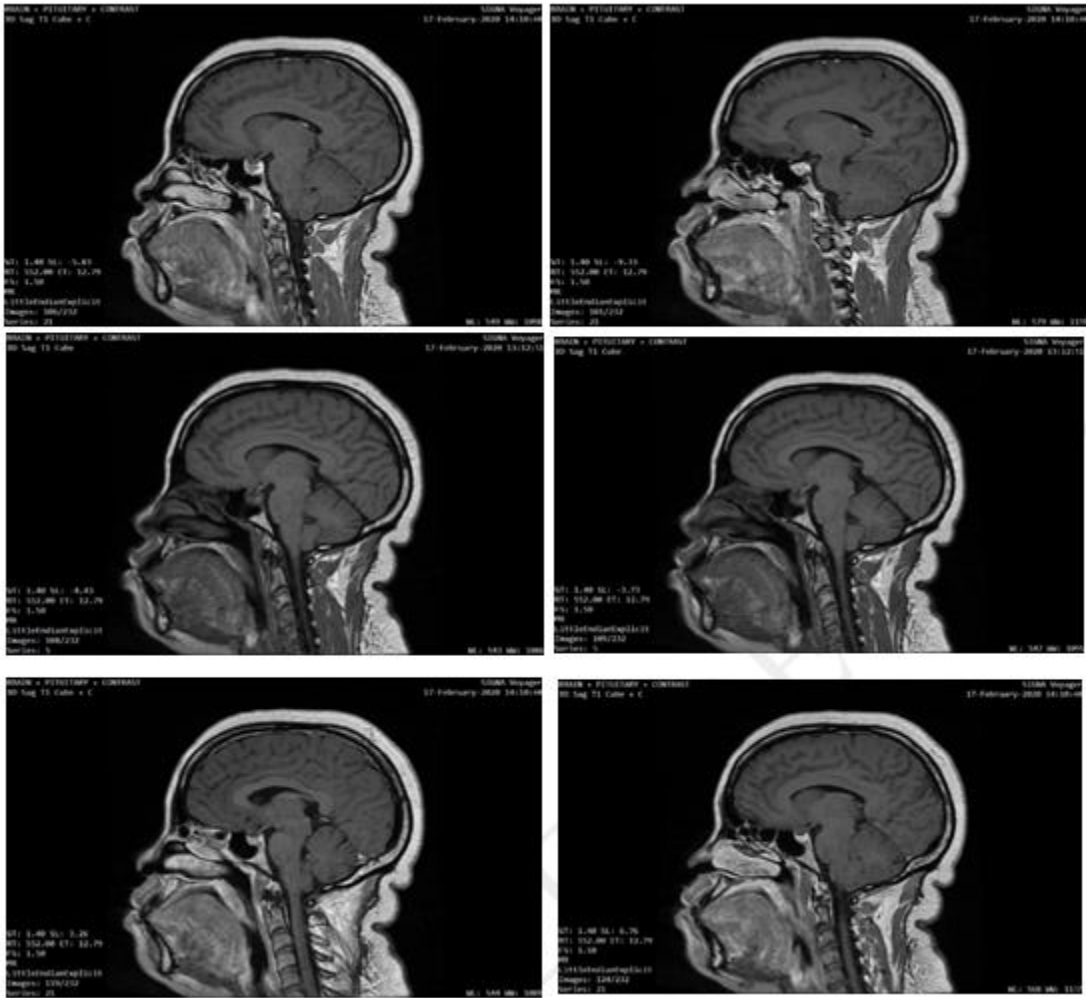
Baseline magnetic resonance imaging (MRI) showing the multilayer sagittal sections of the patient with an uncalcified mass on the sella turcica pushing anteriorly and downward. .
